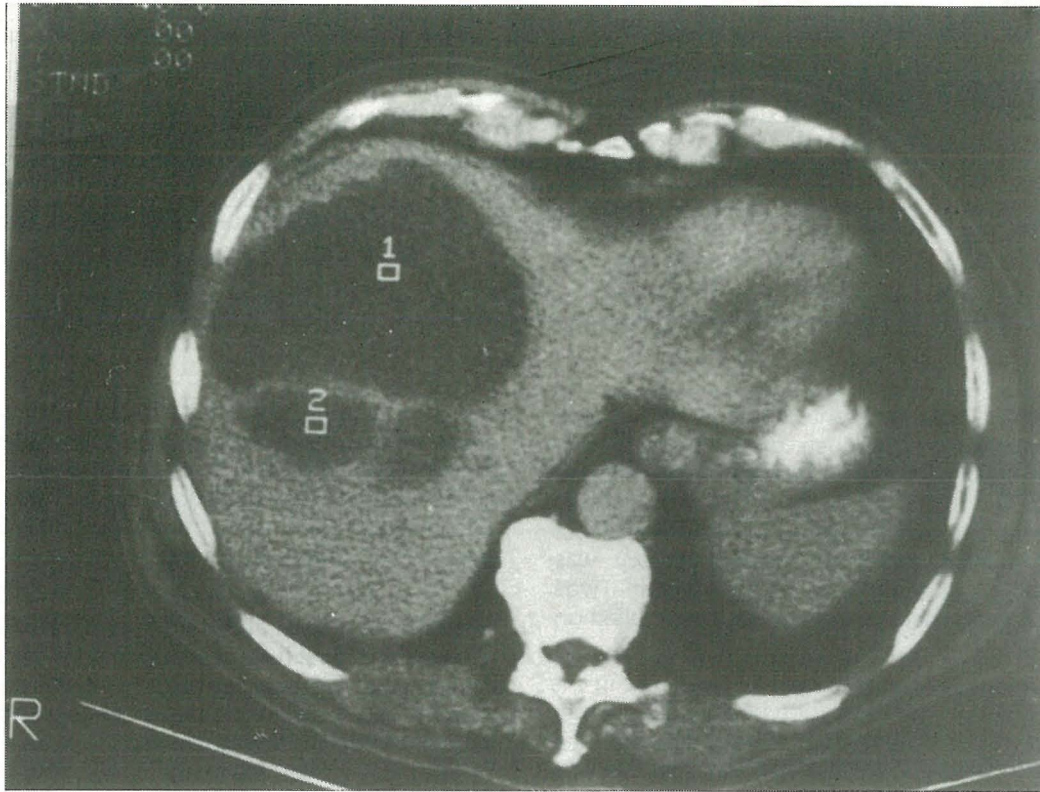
CT Scan at level of T12
